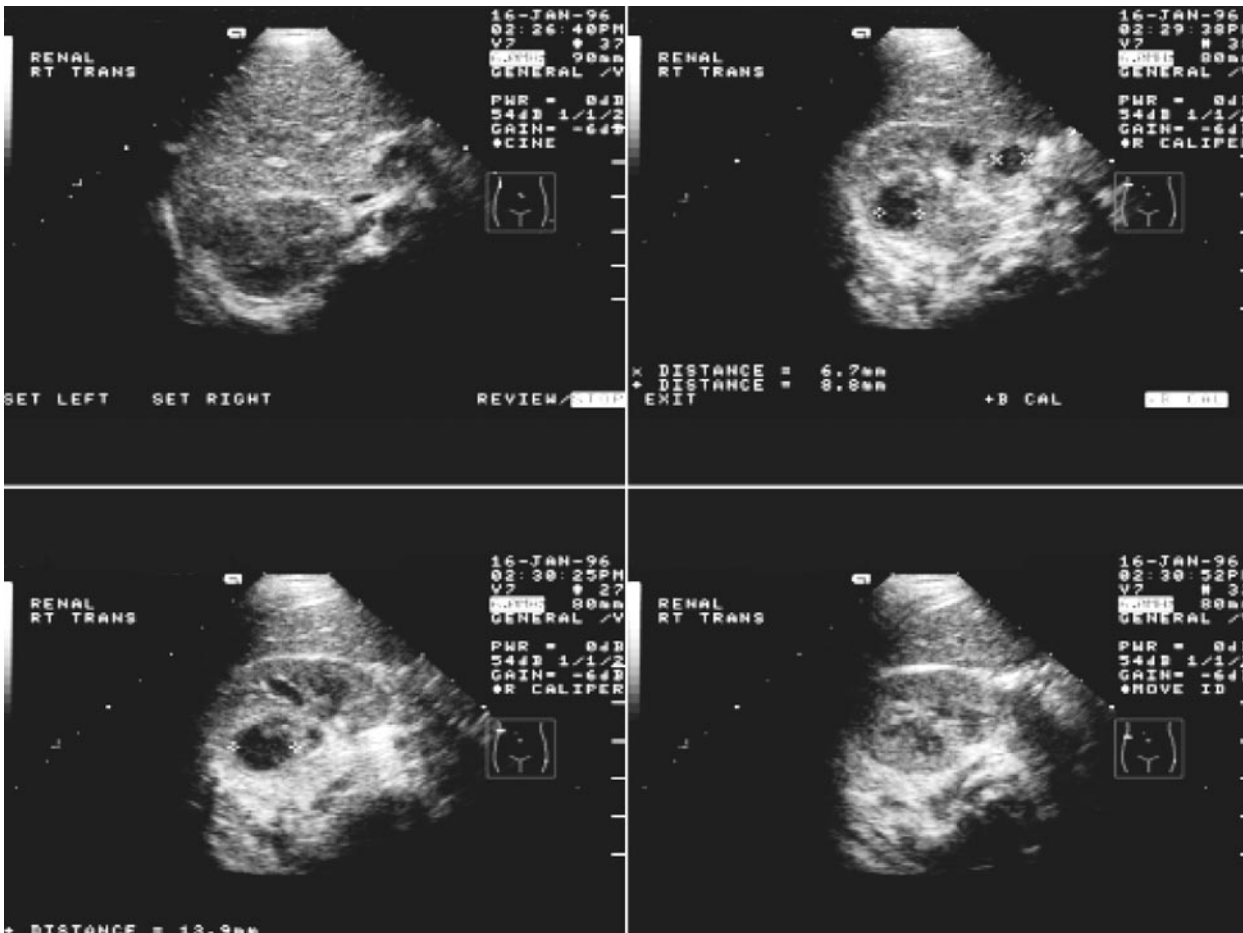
On ultrasound, the infant has markedly dilated kidneys due to renal collections. A diagnosis of pyelonephritis with renal abscess formation was made. Surgical intervention was required in this case.
